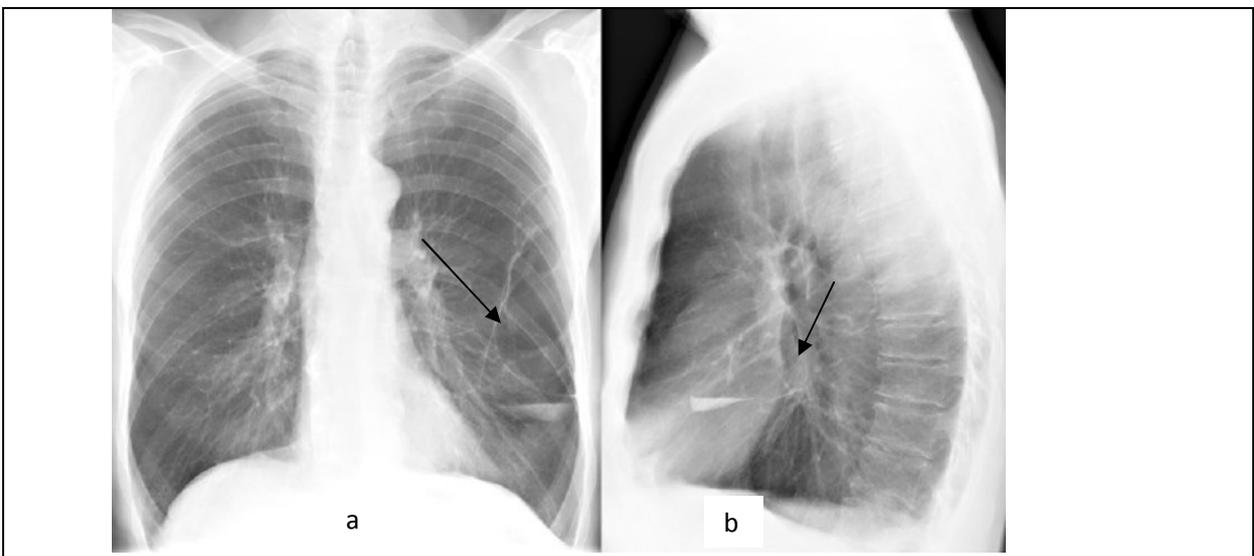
Survey radiographs of lungs in a posterior-anterior (a) and left lateral projections (b). The limited radiolucent zone with horizontal level of a liquid (arrow) in lateral part of the left pulmonary field of incorrectly oval form with thin accurate walls, lateral wall merges with a chest wall. Huge bullous emphysema the left lung.
